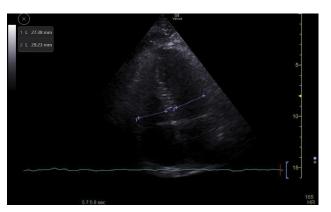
The apical four-chamber view and ventricular diameter measurements.
